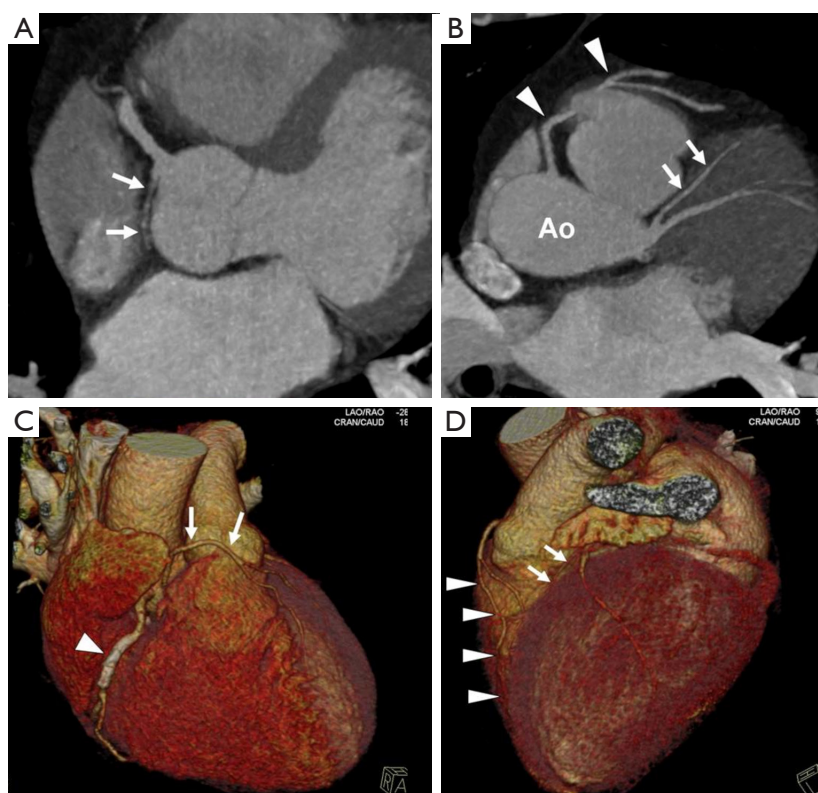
(A) Axial CT image at the level of the RCA origin. The circumflex coronary artery (arrows) has an anomalous origin from the RCA, follows a retro-aortic course and occludes proximally; (B) axial oblique CT maximal intensity projection (6 mm thick) image. The LAD (arrows) is short, disease free, occupies the proximal interventricular groove and gives a single diagonal branch. An anomalous vessel is seen arising from the right coronary sinus separate to the RCA and coursing anterior to the right ventricular outflow tract; (C) volume rendered CT image showing the origin of the “long LAD” (arrows) from the right coronary sinus separate to the RCA; (D) volume rendered CT image showing the “short LAD” (arrows) in the proximal interventricular groove and the long LAD (arrowheads) which occupies the distal interventricular groove. Note the stent in the mid portion of the RCA (arrowhead). RCA, right coronary artery; LAD, left anterior descending; CT, computed tomography.
